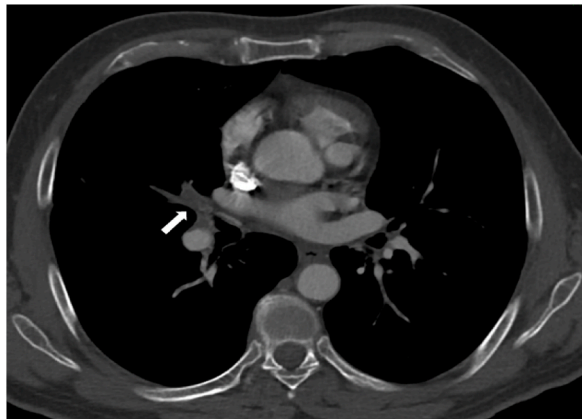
Same CTA examination, in a scan acquired at the pulmonary veins level, demonstrates other peripheral segmental branches' involvement, with occlusion of the pulmonary arterial branches for the middle lobe (white arrow). These may be findings of SIAP advanced stages.
